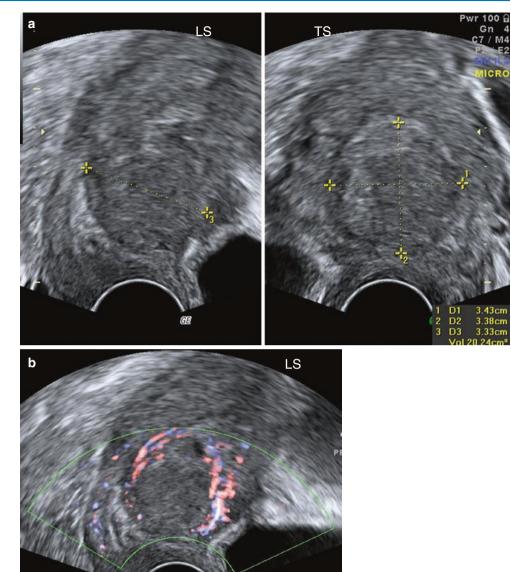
Vascularity of fibroids. (a, b) Fibroids showing typical peripheral vascularity. (c) Atypical fibroid with significant internal vascularity. (d) 3D power Doppler with glass body display showing the vascular morphology in fibroids with high vascularity
